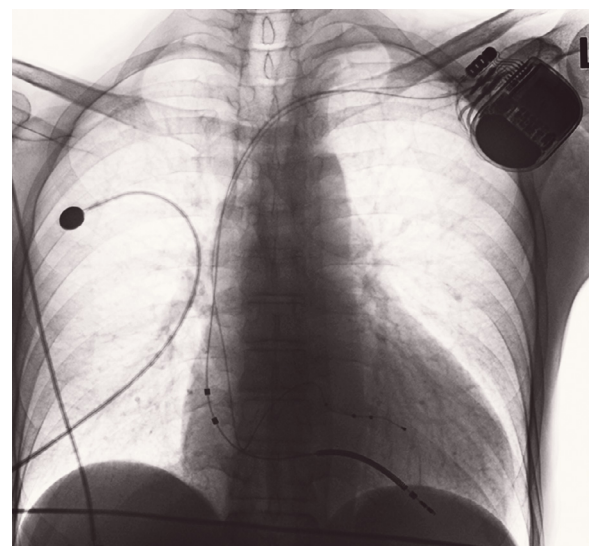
Chest X-ray of a patient suffering from dilatative cardiomyopathy after an upgrade from DX ICD to CRT-DX with a quadripolar coronary sinus lead.
